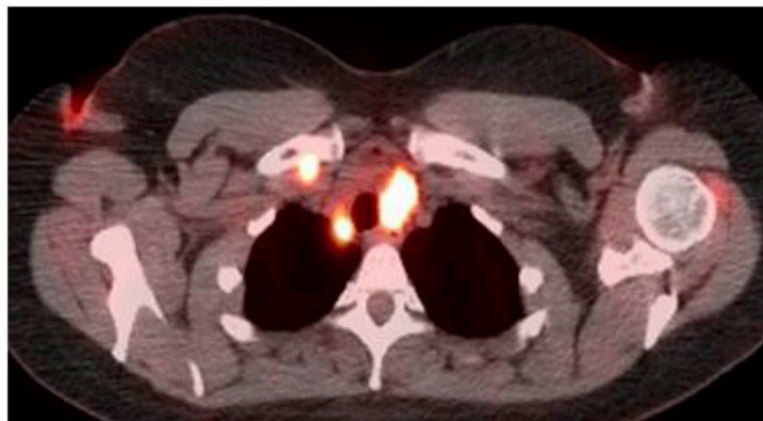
Positron emission tomography/computed tomography showing a hypermetabolic right supraclavicular lymph node.
